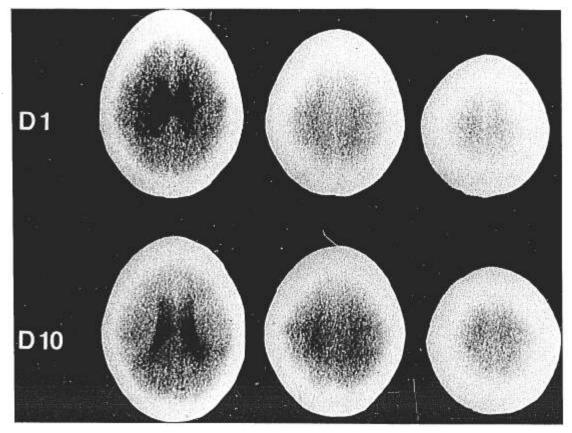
Uninfused CT scans day 1 (D1) and day 10 (D10). Interhemispheric stripe of increased density disappears in higher images on repeat scan at ten days, confirming subarachnoid hemorrhage on initial scan.
